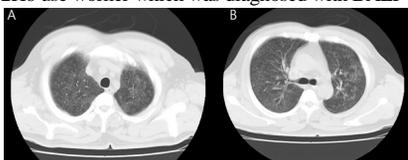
Chest computed tomography on admission showed multiple ill-defined tiny centrilobular nodules and multifocal patchy ground glass opacities in both lungs.
